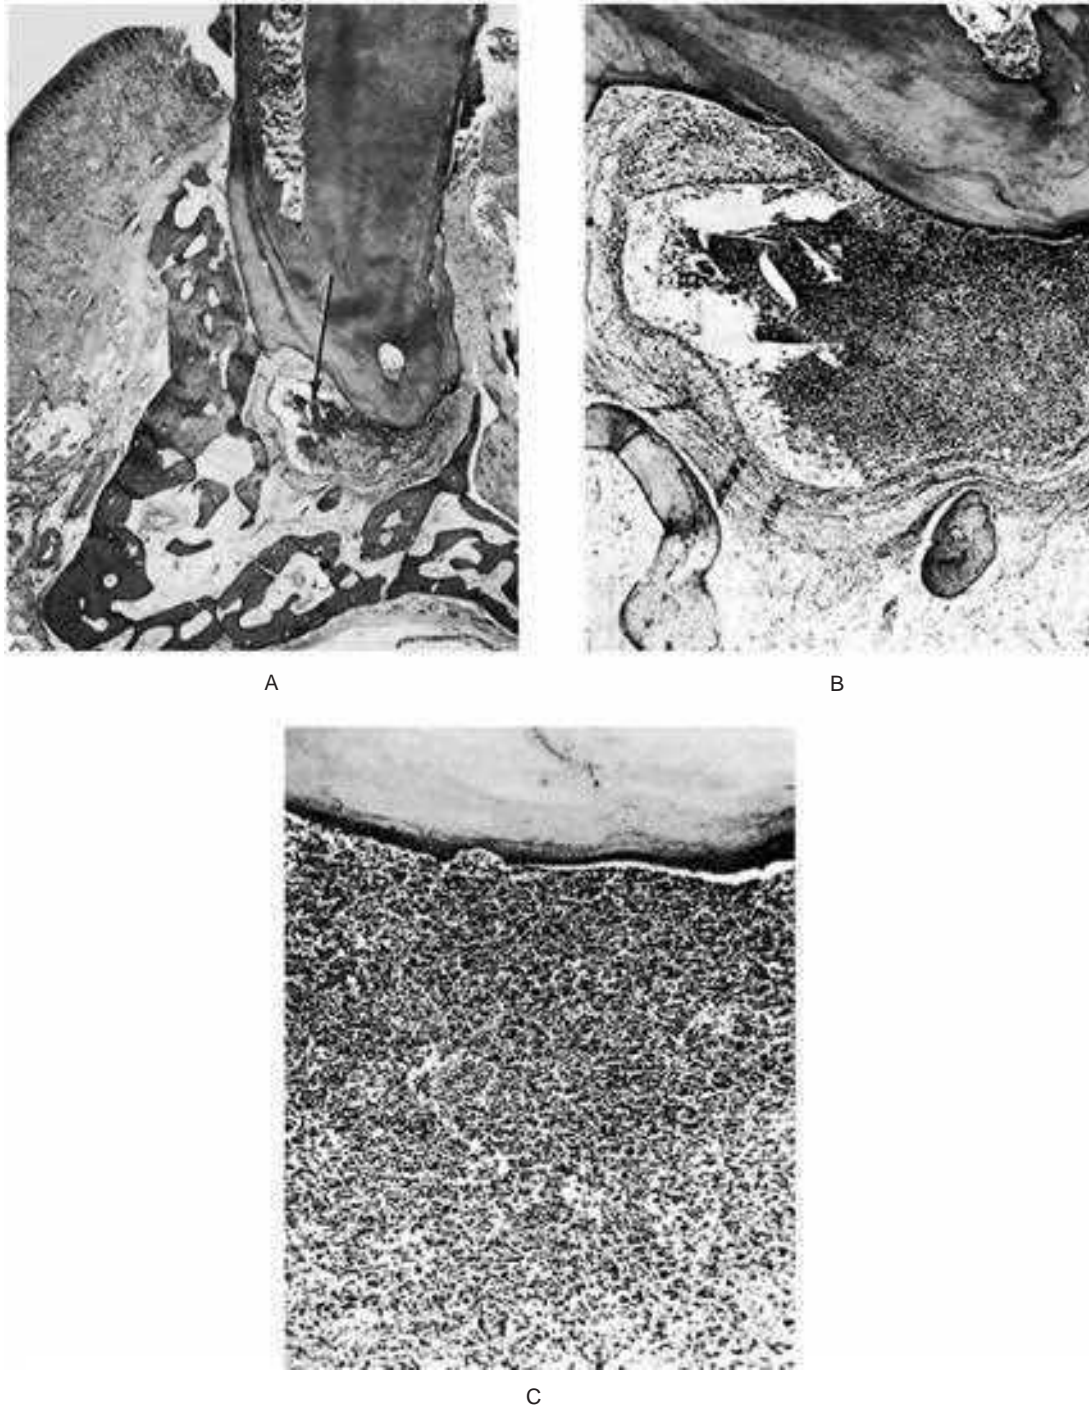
Chronic periapical abscess.
